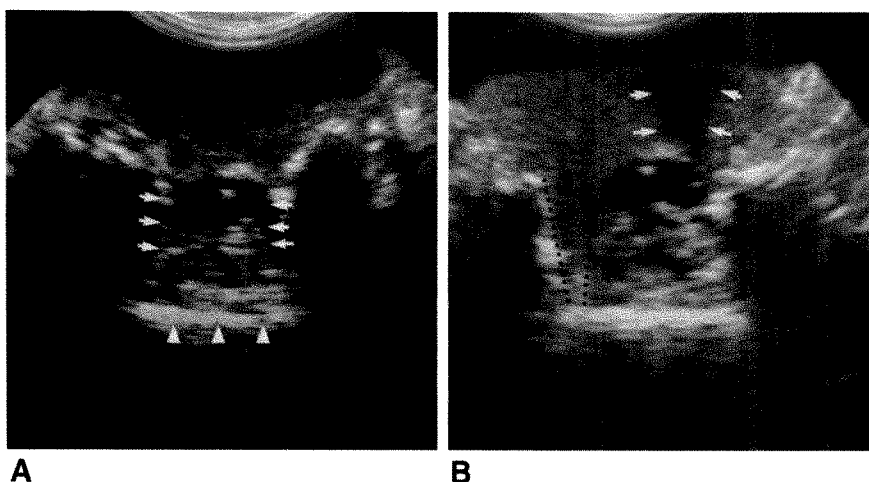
Canal stenosis: residual bony compression of thecal sac at multiple levels in a patient with previous surgery. Sonography was performed after bilateral laminectomies and facetectomies in patient with multiple-level canal stenosis.
